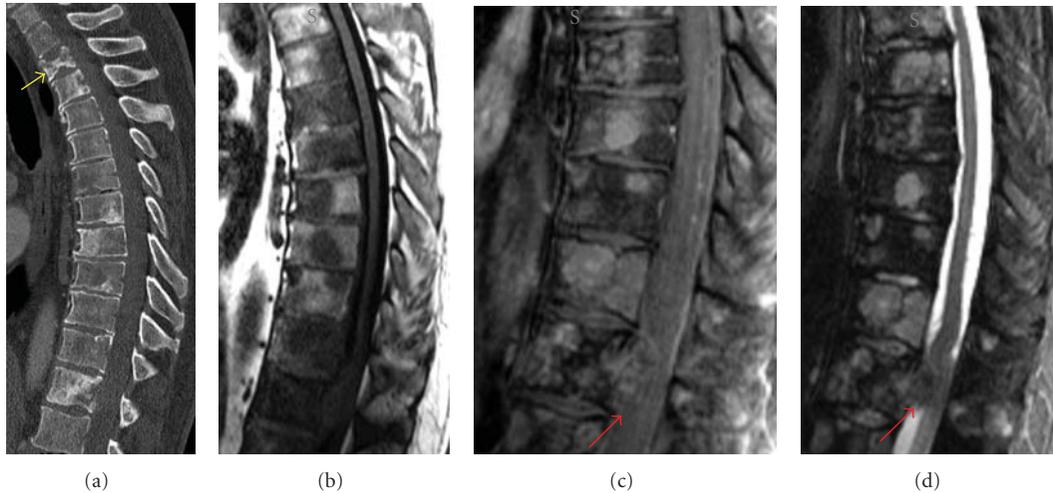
Sagittal CT reformation (a) shows multiple lytic and blastic metastatic breast cancer lesions in the thoracic spine with a compression fracture in the upper thoracic spine (yellow arrow). Sagittal T1-weighted image (b) shows multiple hypointense lesions, many of which enhance on the postcontrast T1-weighted MR (c). The STIR image (d) depicts both hyperintense (lytic) and hypointense (blastic) lesions. A mildly enhancing epidural component compresses the thecal sac (red arrows).
